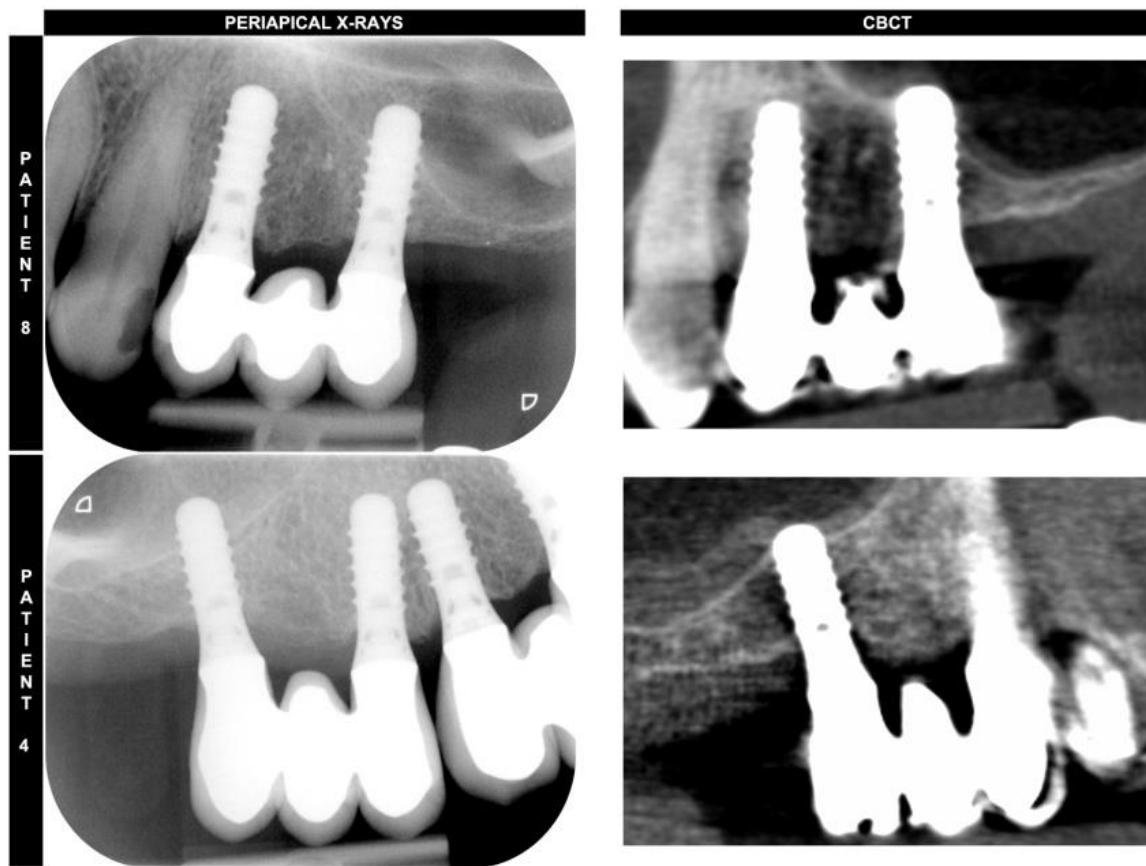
Overestimation of implant protrusion into the sinus on periapical X-rays in comparison with CBCT images (patient 8, implant 26 and patient 4, implant 16).
